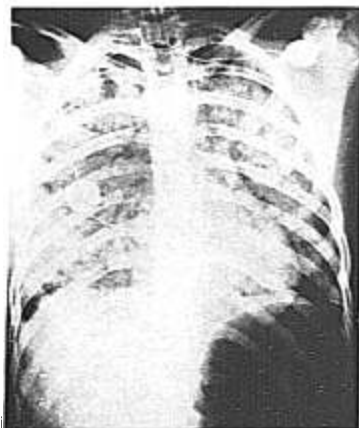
Chest x-rays. *Above, left*, six hours after aspiration and prior to the application of PEEP; *below, left*, eight hours after institution of PEEP; *above, right*, at the time of discharge.
